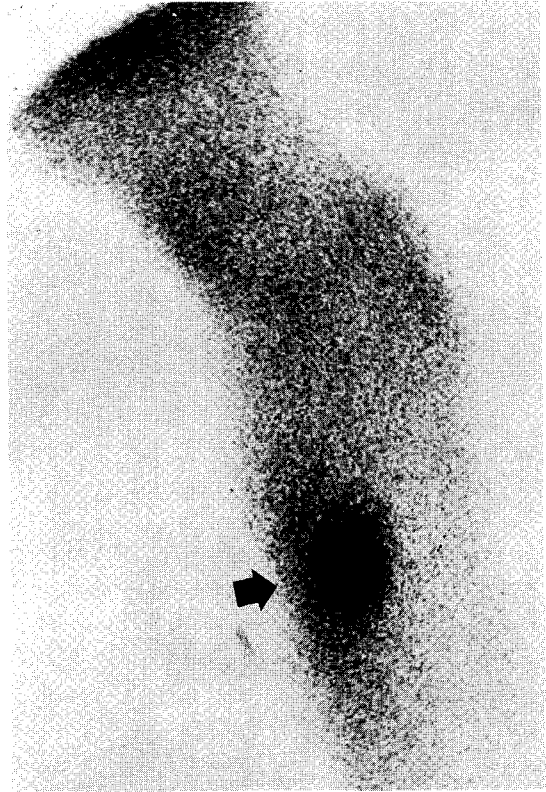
Pinhole bone scintigram of left proximal femur showed discrete hotter spot within hot area (black arrows).
